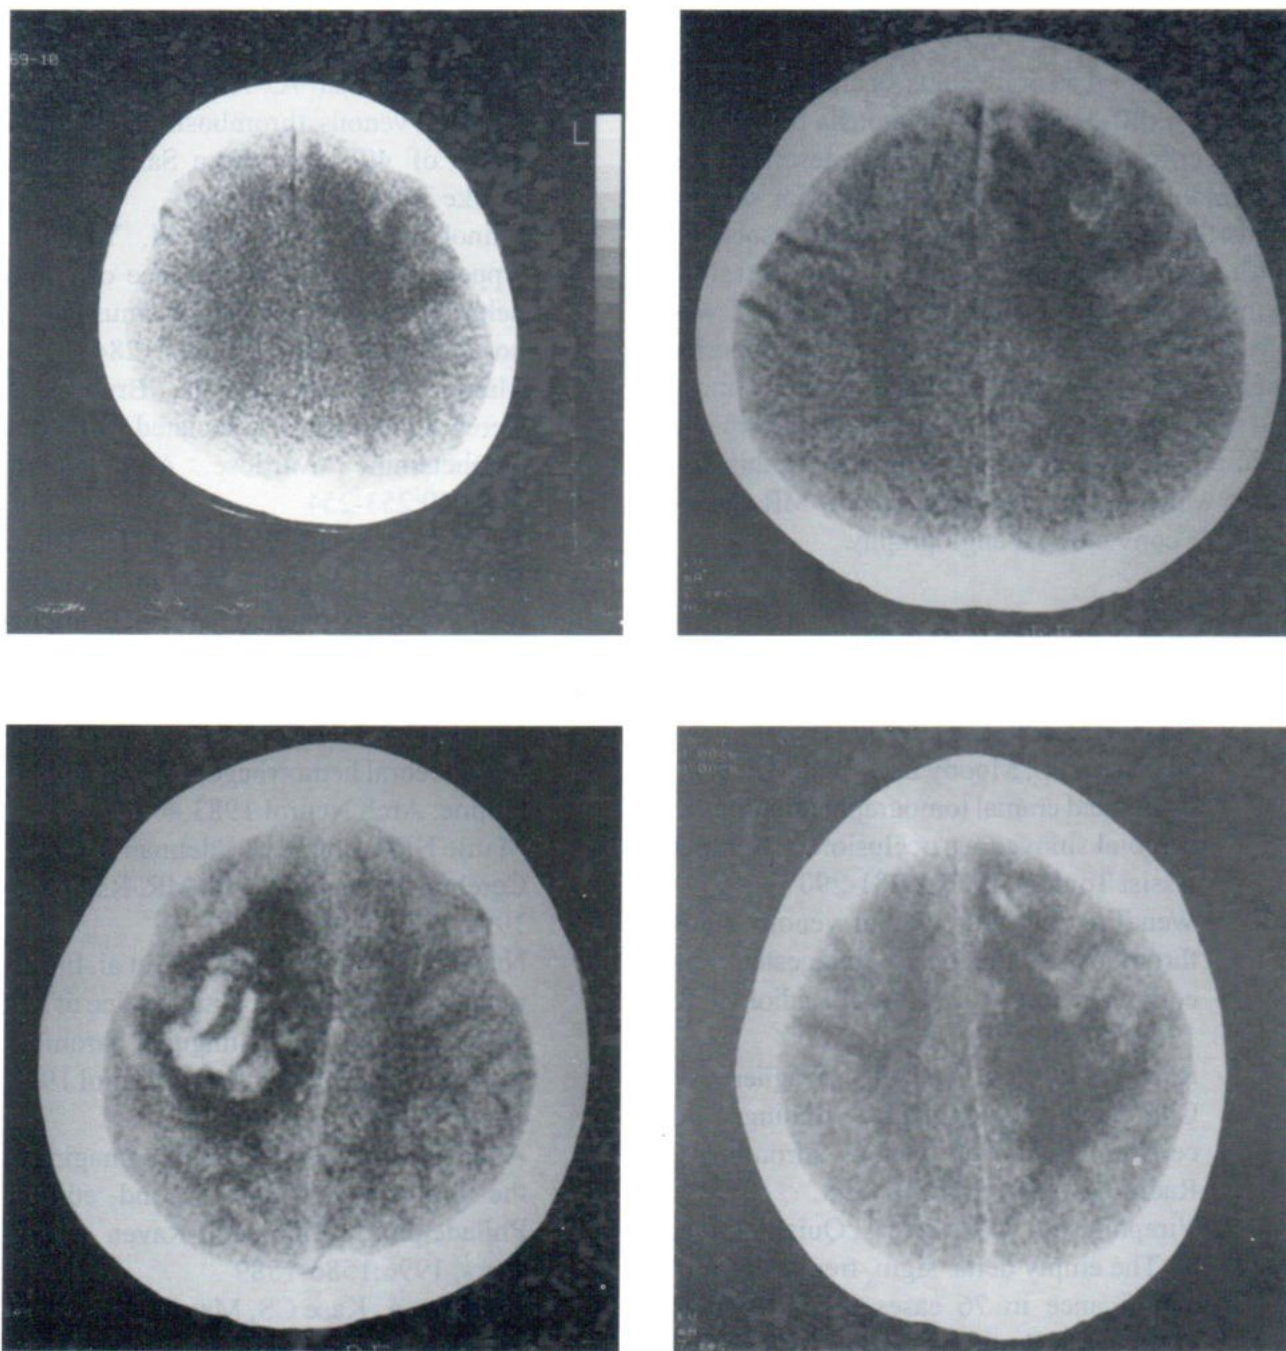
CT findings of venous infarcts with and without associated intraparenchymal hemorrhage in four different cases.
